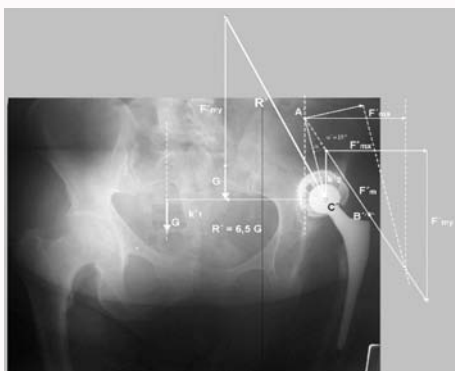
Postoperative radiograph of the pelvis. Left hip with graphical description of hip biomechanics. To achieve biomechanical balance, total loading of the hip (force R') should be 6.5 G, but abductor muscles can't give such power, and balance is theoretical. That is the reason for limping.
